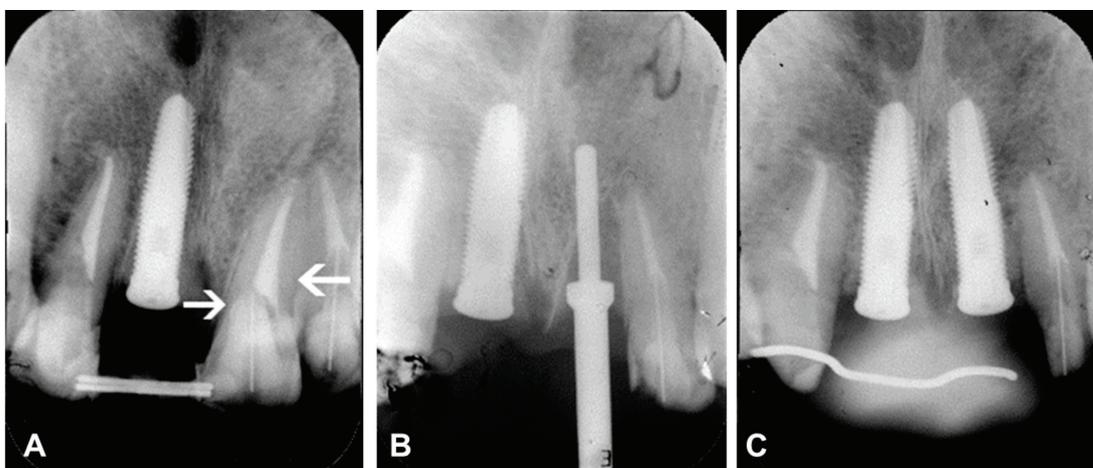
A: Oblique fracture between crown and root of the left central incisor; B: atraumatic extraction and immediate second implant placement into the left upper incisor socket, and C: Three months postoperative radiographic control after the second implant surgery
